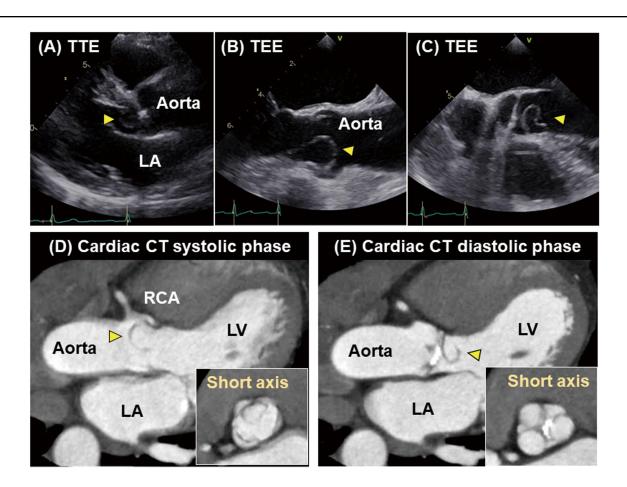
Parachute-like structure flailing back and forth between the left ventricular outflow tract and the sinus of Valsalva. (A) Transthoracic echocardiography (TTE). The arrowhead indicates parachute-like structure. (B,C) Transesophageal echocardiography (TEE). Arrowheads indicate parachute-like structure. (C,D) Cardiac computed tomography (CT) during the systolic (D) and diastolic (E) phases. Insets show short axis images of the aortic valve. Arrowheads indicate parachute-like structure. LA, left atrium; RA, right atrium; RCA, right coronary artery.
